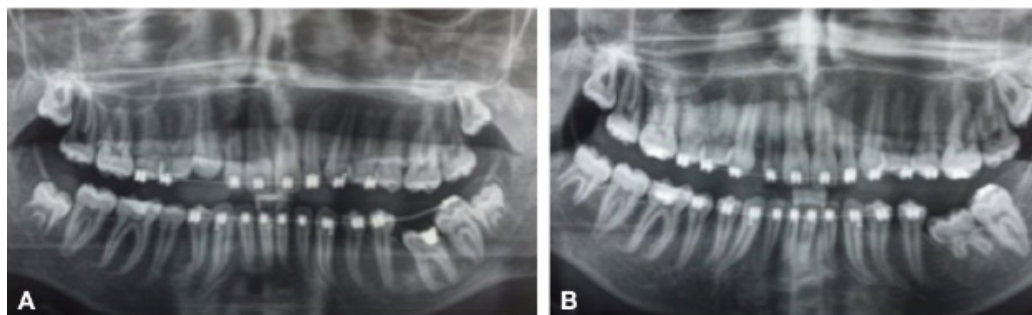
A. Orthodontic treatment panoramic radiograph. B. Panoramic radiograph after 3.6 extraction and 3.8 autotransplantation.
